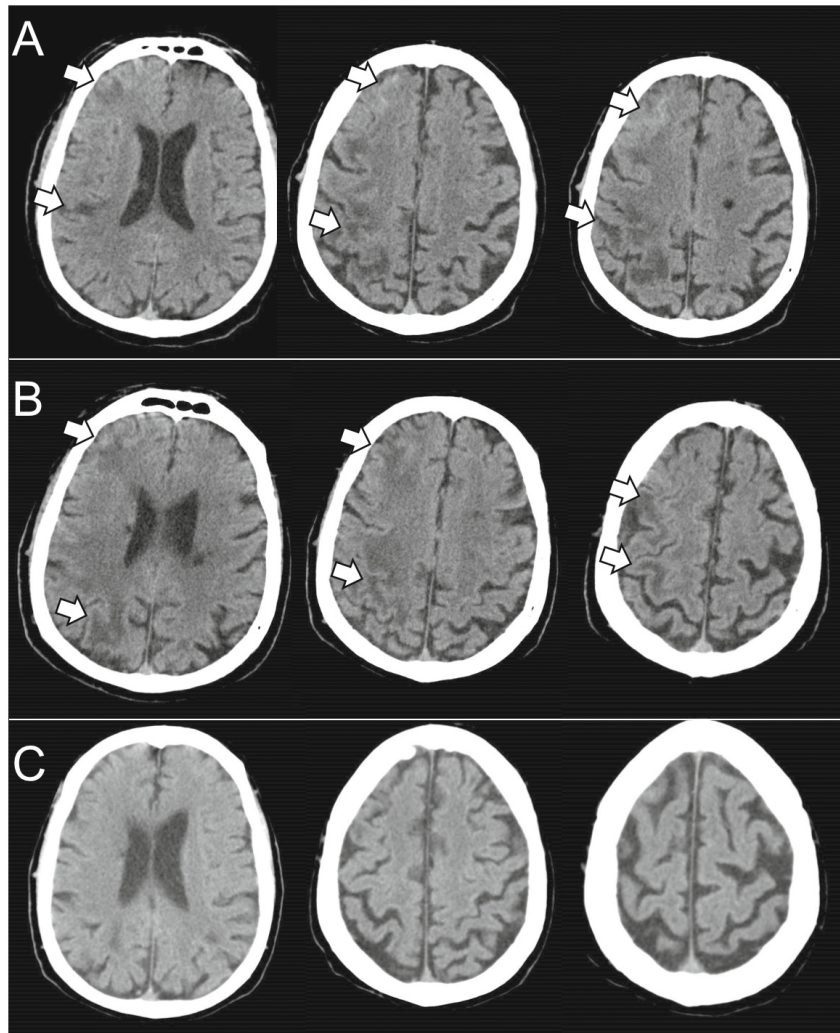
Evolution of the patient's brain computed tomography. A: Subtle signs of right frontal and parietal edema (arrows) on arrival at the ED. B: Worsening of edema, 24 hours later, during hospitalization. C: Normalization of neuroimaging at 6 weeks.
